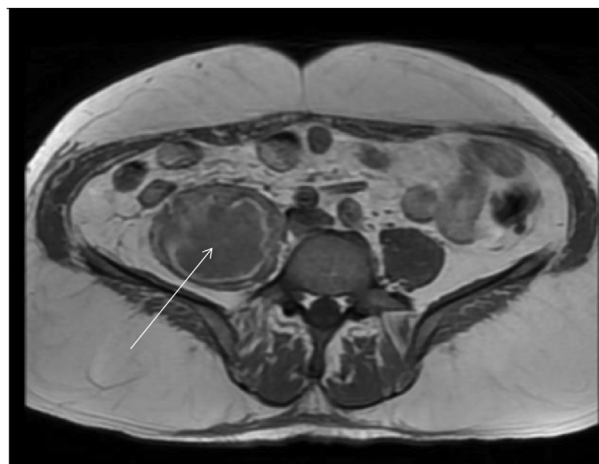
Axial view of a pelvic MRI with the white arrow pointing to the large intramuscular fluid collection.
